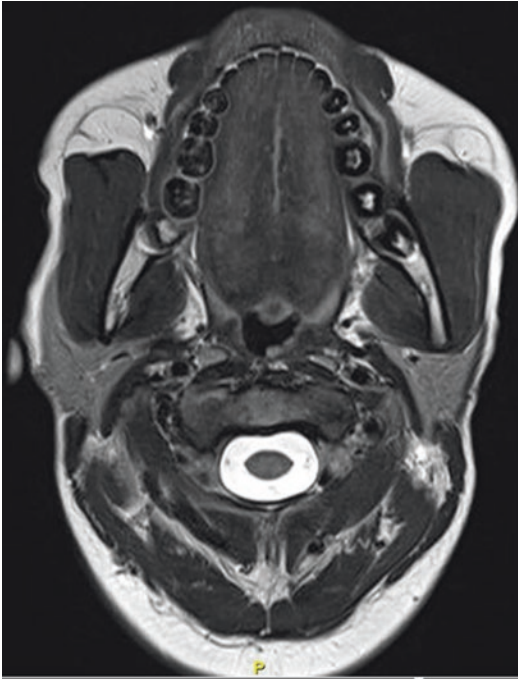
Bilateral masseteric hypertrophy causing facial swelling as viewed on MRI
